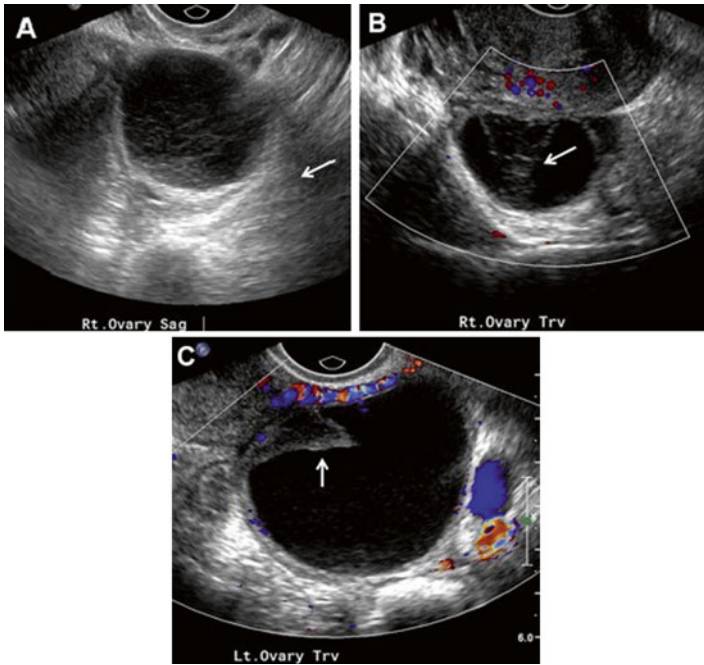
Hemorrhagic ovarian cysts. (a) Transvaginal ultrasound demonstrates a thin-walled hypoechoic cyst with a “lacelike” pattern of internal low-level echoes representing fibrin formation from lysis of RBCs (arrow). (b, c) Transvaginal ultrasound demonstrating a later stage of hemorrhagic cysts, which contain retractorile clot seen as heterogeneous iso-echoic to hypoechoic irregular-shaped mural foci (arrows) without Doppler flow (Reprinted from Amirbekian and Hooley [51], with permission from Elsevier)
